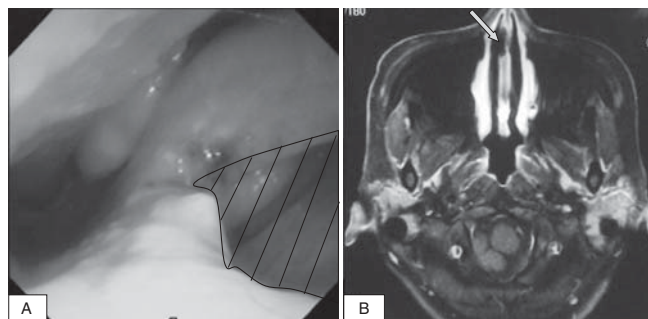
A Laryngoscopic image of the nasal septum perforation, and B enhanced magnetic resonance imaging of the head. The shaded portion in A is the defect in the nasal septum, and the arrow in B indicates the same defect
